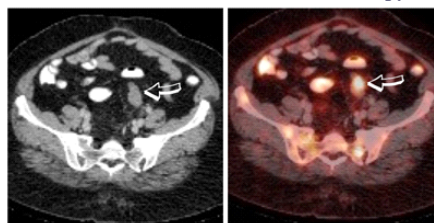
Fused PET-CT image at the level of pelvis revealing nodular FDG-avid pelvic peritoneal deposits which also showed regression in size after chemotherapy (Figure not shown).
